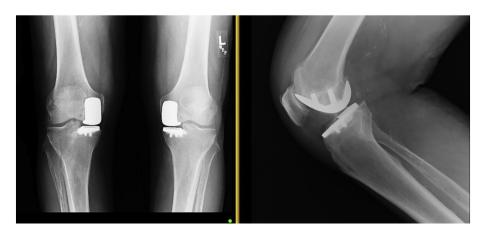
Post-operative radiographs following primary right unicompartmental arthroplasty.
